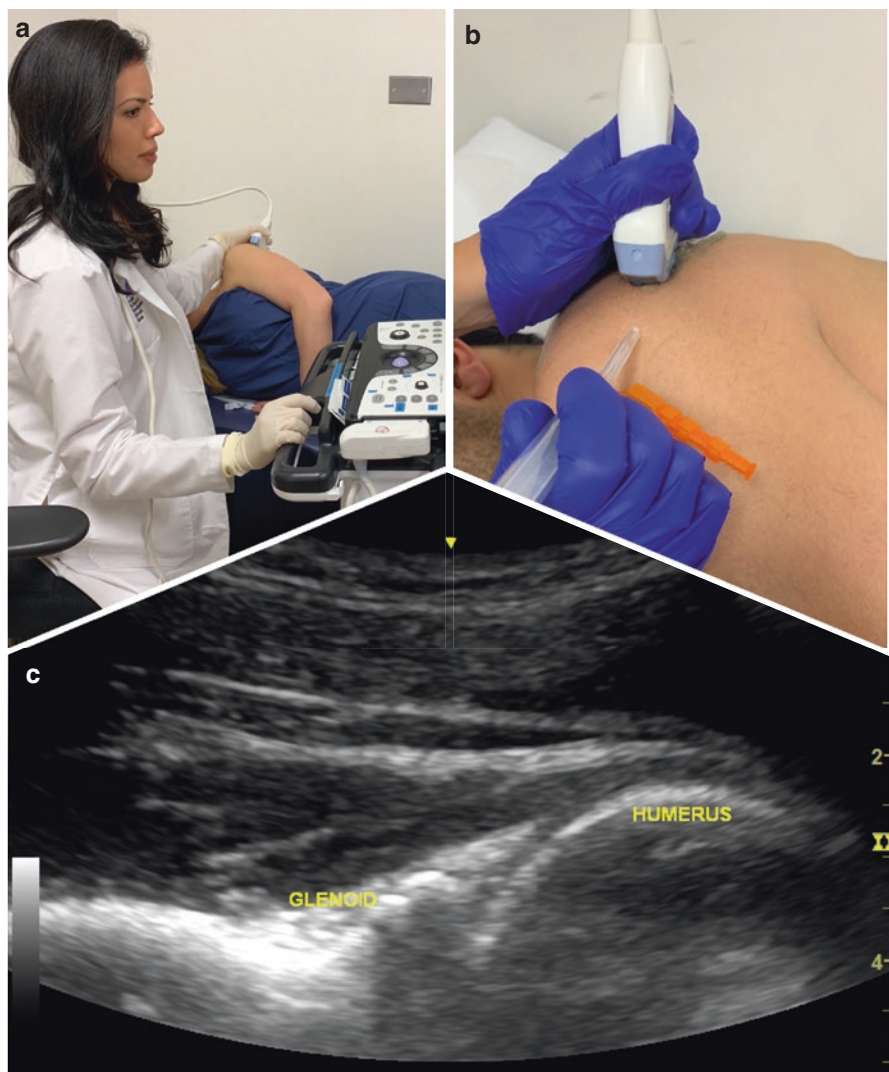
(a) Patient position for ultrasound guided glenohumeral injection. (b) Ultrasound transducer and needle alignment for glenohumeral injection. (c) Ultrasound image of glenohumeral joint with patient sidelying
